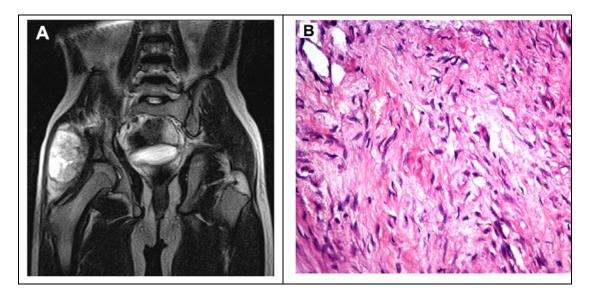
MRI of the index case showing lengthening of the neck of right femur. Figure 2B. Neurofibroma with myxoid matrix.
